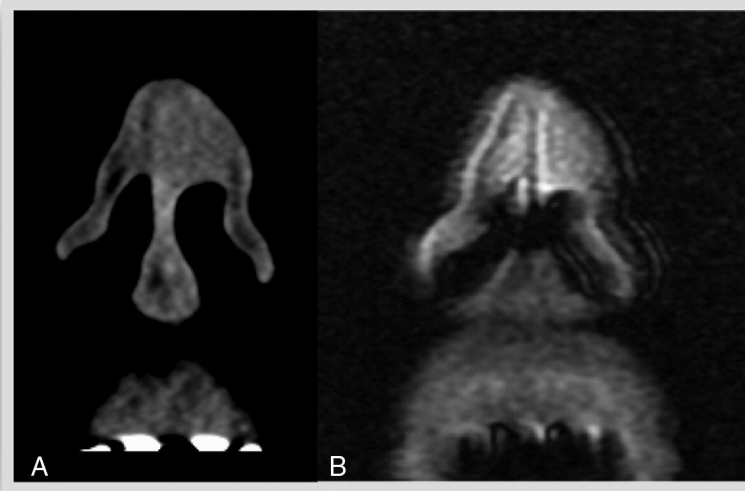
Imaging following pre-operative chemotherapy and external beam radiation showing anterior nasal tumor with suggestive of cartilage and skin involvement. (A) Non-contrast coronal CT showing anterior nasal mass. (B) T1 coronal MRI with contrast showing enhancement of nasal mass. Compared to the right side, the plane between cartilage and nasal skin is not well preserved suggesting chondrocutaneous involvement. Courtesy of Dr. Roy Holliday, Department of Radiology at New York Eye and Ear Infirmary of Mount Sinai.
